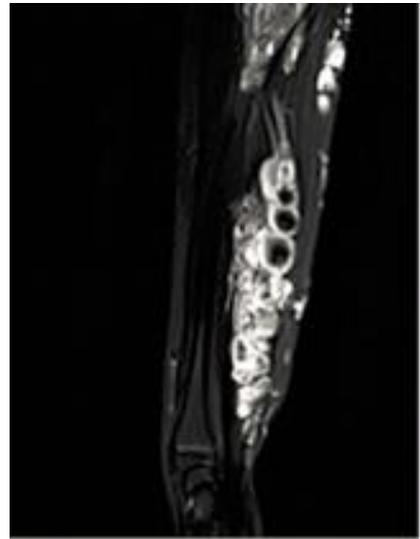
Serial number 17 patient in this study – plain radiograph of the left forearm showing soft tissue density with a few calcifications within them. Fat suppressed coronal STIR images show hyperintense spaces with multiple phleboliths, appearing as STIR hypointense discrete foci.
